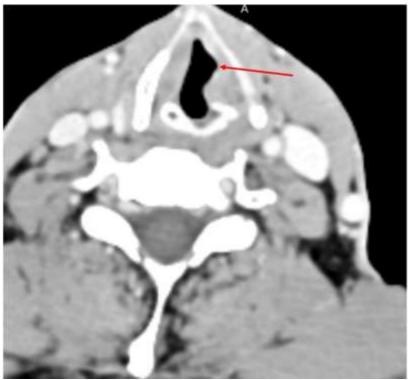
CT Neck Showing Post Contrast Venous Phase Images Dilatation of the Left Lateral Ventricle and Atrophy of the Left Thyroarytenoid.
